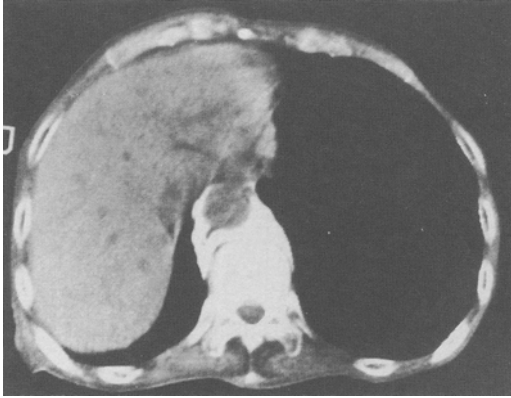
Using CT scanner with contrast medium, optimum result was obtained when radiopaque solution spread to encircle the aorta.
